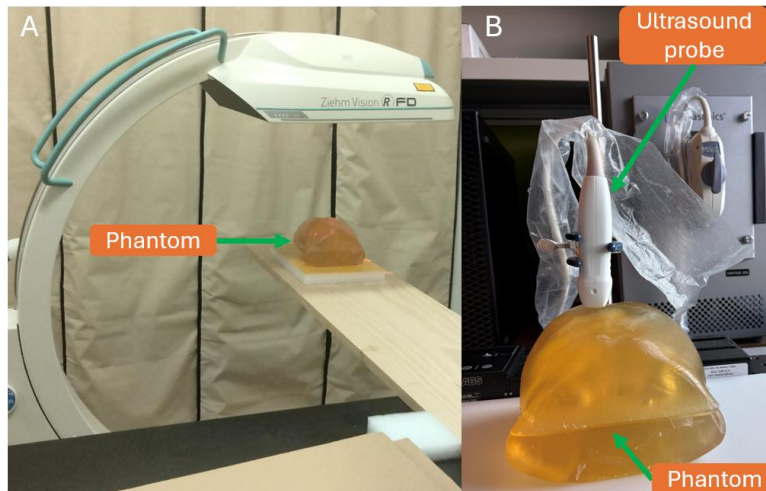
Experiment setup of (A) CT imaging, (B) US imaging.
